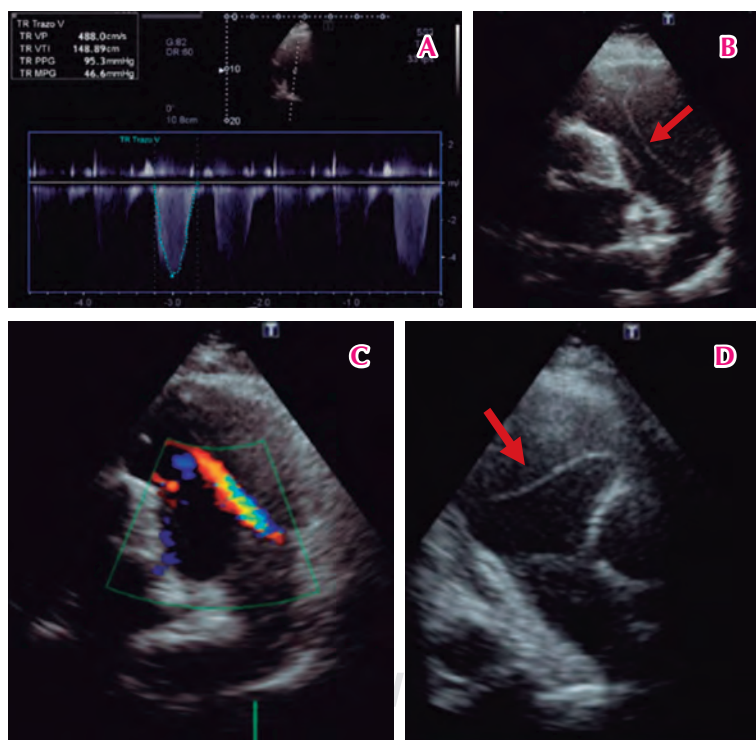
Transthoracic echocardiogram. A) Tricuspid regurgitation with a peak velocity (Vmax) of 4.8 m/s, and high echocardiographic probability of pulmonary hypertension. B to D) Great vessels short axis view. The arrow marks the dissecting flap in the pulmonary artery. C) Shows turbulence in Doppler color at the dissection point.
